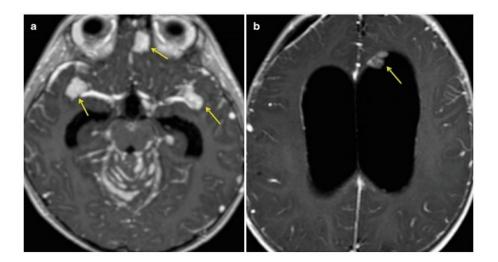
(a) Axial T1-weighted postcontrast images in metastatic medulloblastoma with cerebellar leptomenigeal enhancement and nodular intracranial metastases in subfrontal and temporal region (arrows); (b) Axial T1weighted postcontrast images in metastatic medulloblastoma with a lesion in the subependymal region of the lateral ventricules (arrow).
